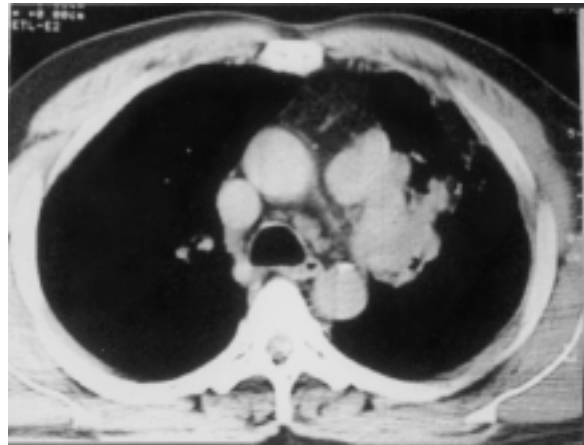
CT scan chest; central bronchogenic carcinoma with mediastinal lymph node enlargement.
